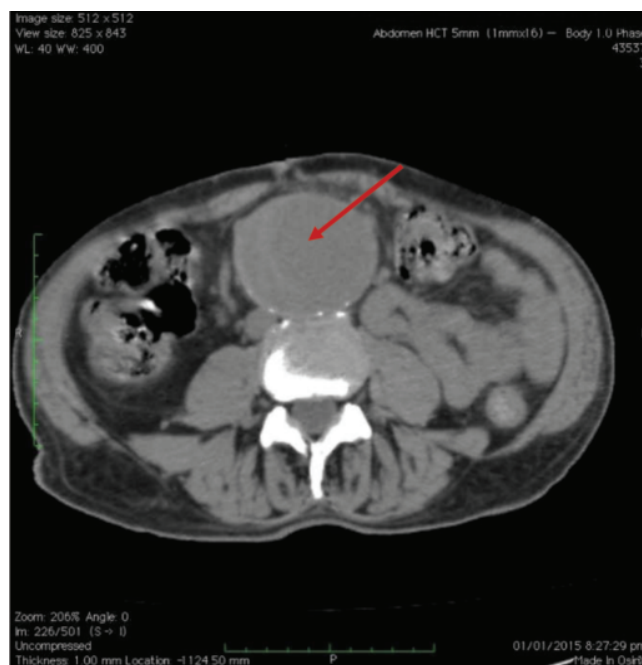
CT scan abdomen without Contrast. Arrow pointing toward aortic aneurysm with a big thrombus.
